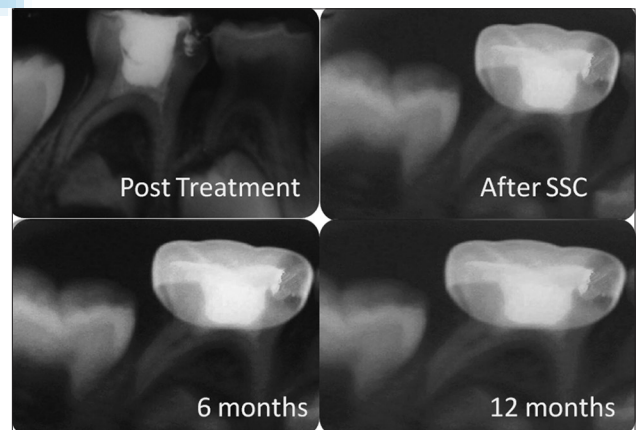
Follow-up radiographs after Diode laser and MTA pulpotomy
